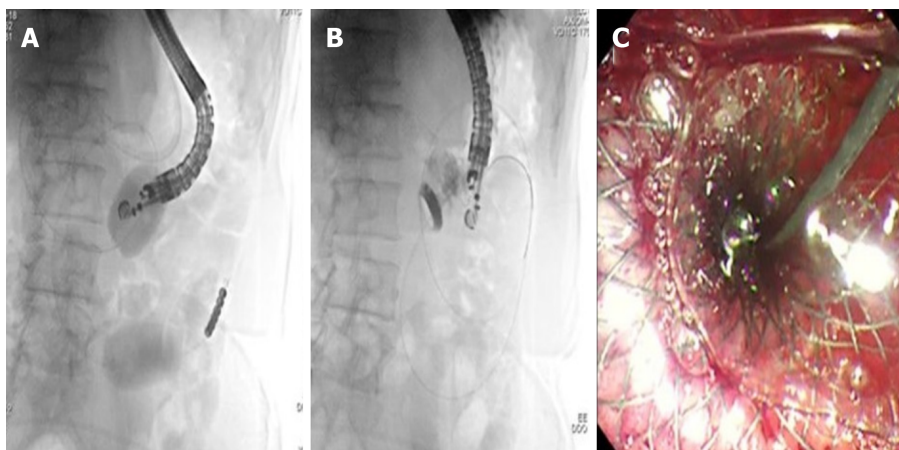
Endoscopic ultrasound-guided gastroenterostomy with the double balloon occluder. A: The double balloon occluder in place distending the small bowel in between; B: Endoscopic ultrasound-guided placement of lumen-apposing metal stent between the stomach and jejunum; C: Final endoscopic appearance of lumen-apposing metal stent.
